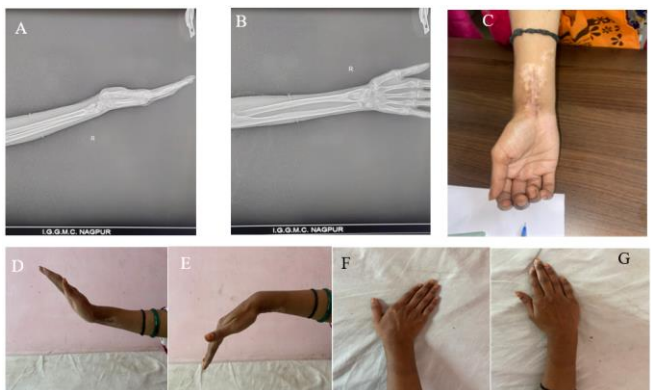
Six months postoperative (A) lateral, (B) AP x-rays. Clinical images of (C) scar condition, (D) Dorsiflexion of 60°, (E) palmar flexion of 55°, (F) & (G) normal ulnar and radial deviation respectively
